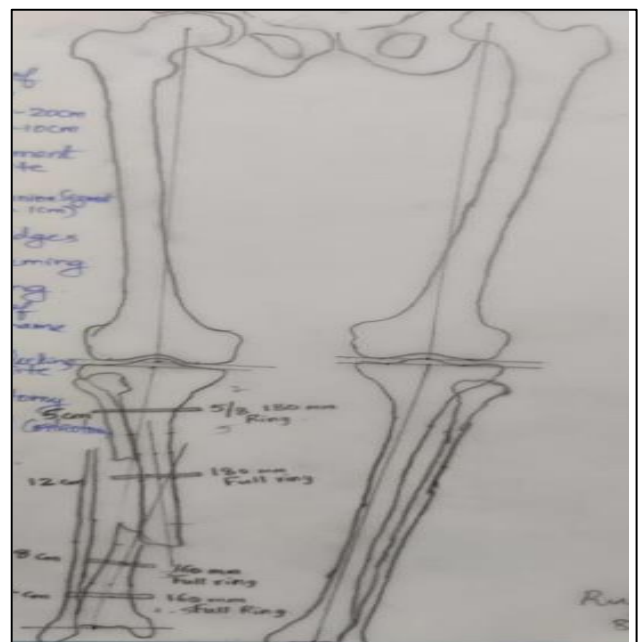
Pre op X-ray tracing.
